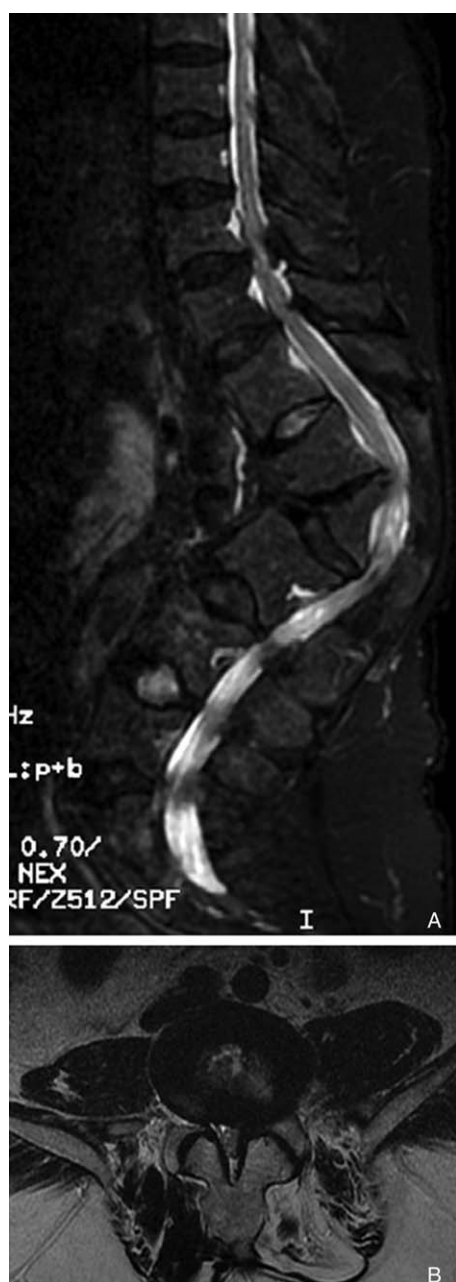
Preoperative magnetic resonance imaging of the thoracolumbar spine. The sagittal view demonstrates multiple-level spinal canal stenosis. The axial view shows spinal canal stenosis due to hypertrophic facet joints and ligamentum flavum.
